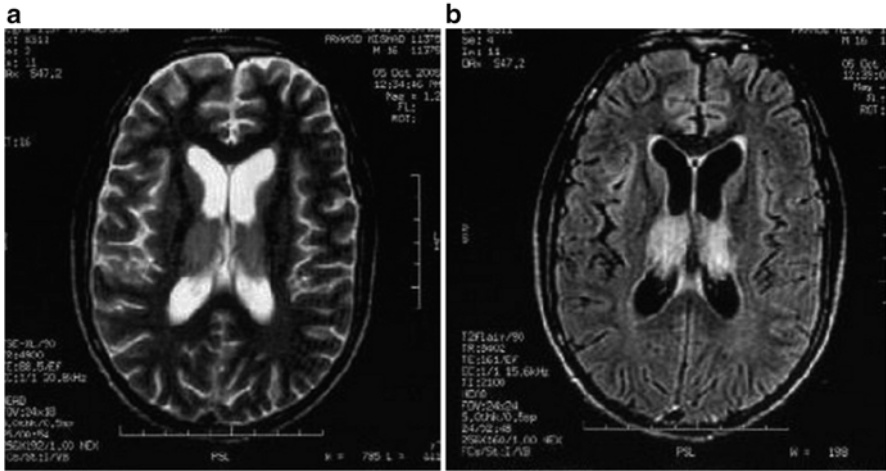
Cranial MRI in axial section shows bilateral thalamic lesion on T2 sequence (a) which is more apparent on FLAIR sequence (b)
